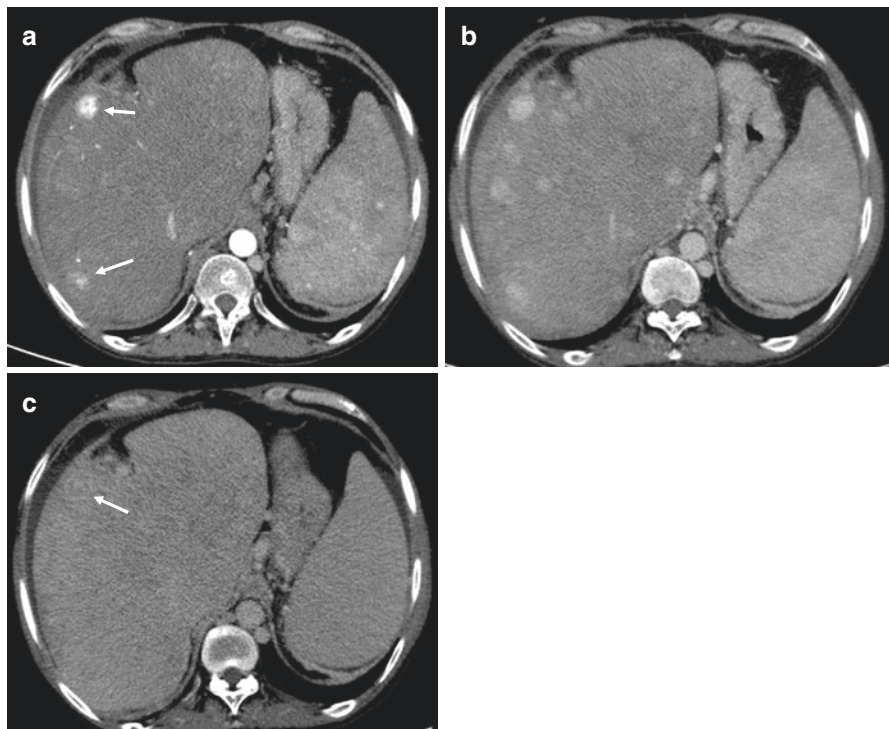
Enhanced CT scan in a 33-year-old patient with BCS at hepatic veins level, showing a dysmorphic liver with BCS signs including enlarged caudate lobe, and HCC nodules. (a) Small hypervascular subcapsular nodule located in segment V, 16 mm in diameter, strongly and homogeneously enhanced on arterial phase. Second hypervascular nodule, with poorly defined outlines in segment VII (arrows); (b) In the portal phase, the segment V nodule is less enhanced, corresponding to a starting washout. Appearance of multiple benign hypervascular nodules; (c) Late-phase washout of the segment V lesion with a slight peripheral capsular enhancement (arrow), homogenization of other benign nodules (with courtesy of Pr SA. Faraoun)
